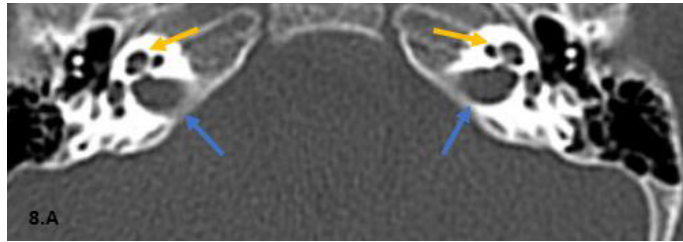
A: axial CT view revealed normal bilateral cochlear morphology (yellow arrows), and normal bilateral diameter of IACs (blue arrows).
